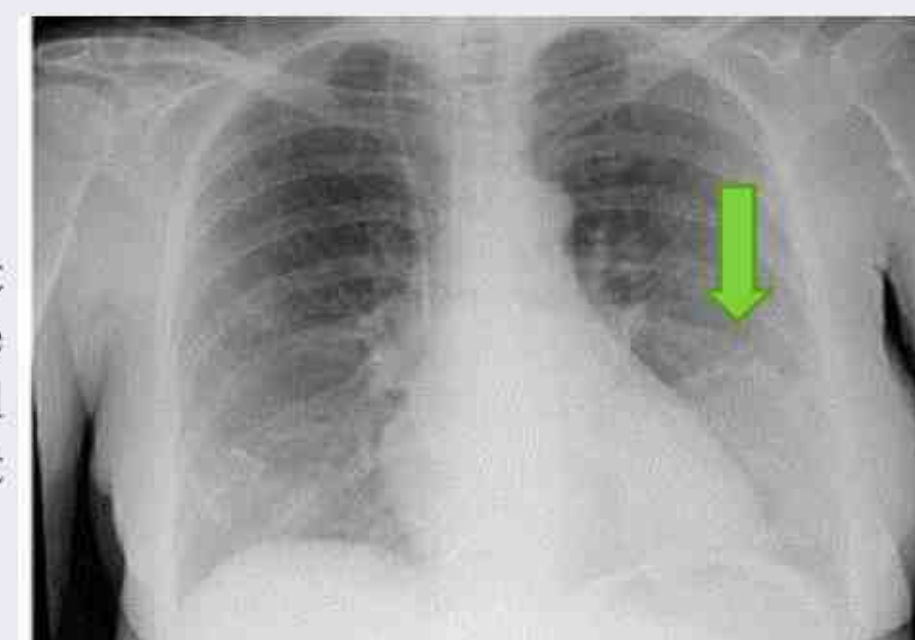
(right) chest radiograph with coarse calcification projected over the left breast shadow /chest wall
